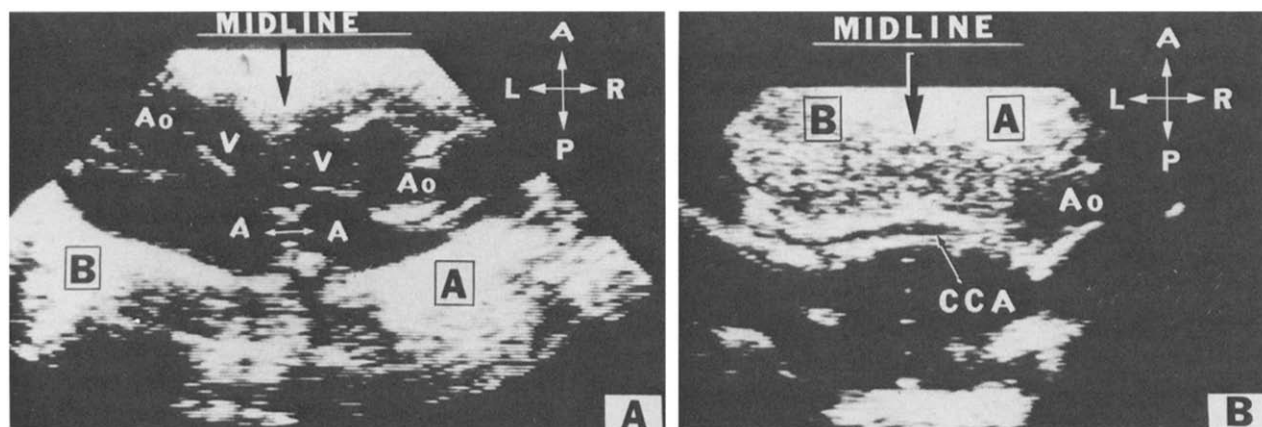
Two-dimensional echocardiograms. [A] = Twin A; [B] = Twin B. Panel A, The bidirectional arrow indicates the cross-midline intertwin interatrial (A↔A) communication. Panel B, Arising from the aorta of Twin A, a coronary artery crosses the midline and is (presumably) supplying Twin B. (See text and Fig. 4A and B.) A = anterior; Ao = aorta; CCA = crossing coronary artery; L = left; P = posterior; R = right; V = ventricle.
